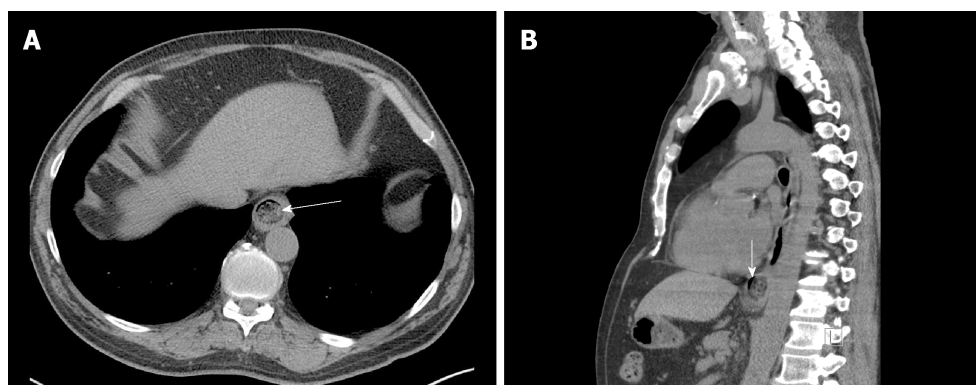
Computed tomography revealing an esophageal food impaction. A: Axial tomogram revealing a food bolus (arrow) in the distal esophagus; B: Sagittal tomogram reveals a sliver of space around the bolus (vertical arrow) suggestive of an opportunity to wedge in the endoscope and employ the push technique or to pass a guidewire (e.g., for the balloon dilation technique).
